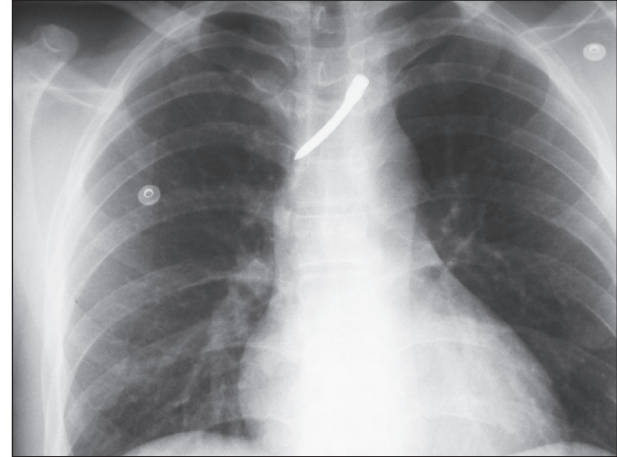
Posteroanterior chest radiograph of a patient with penetrating injury (metal screw) into his anterior mediastinum
